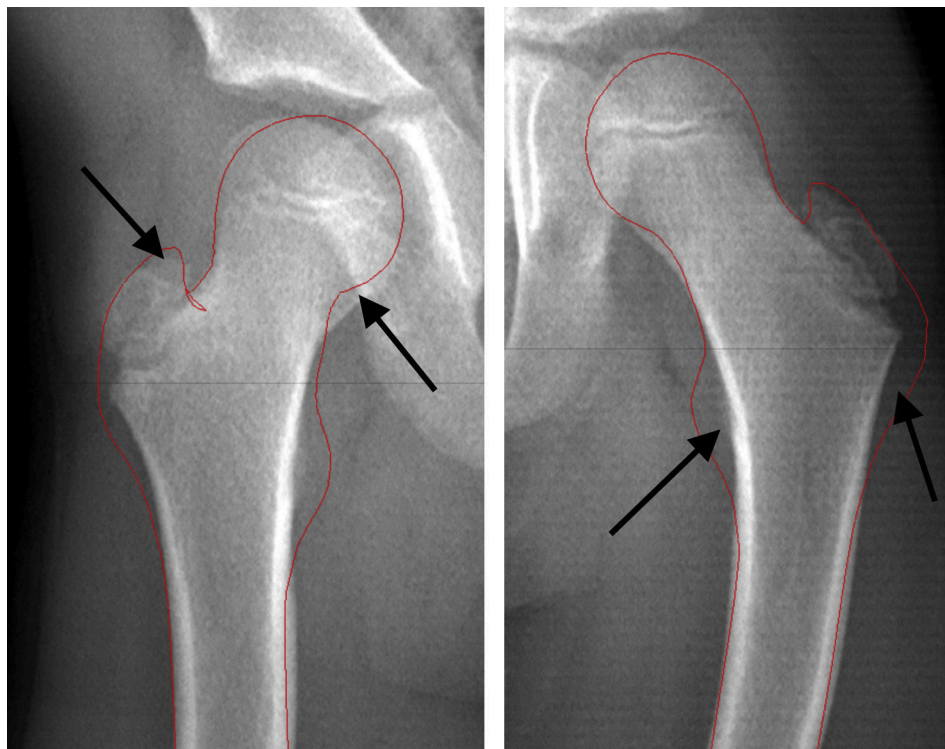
Hip biplanar X-ray at 6 years. Black arrows show the zones with a poor definition: the lesser trochanter is not visible, the femoral head is not round and the femoral neck appears thicker than normal.
